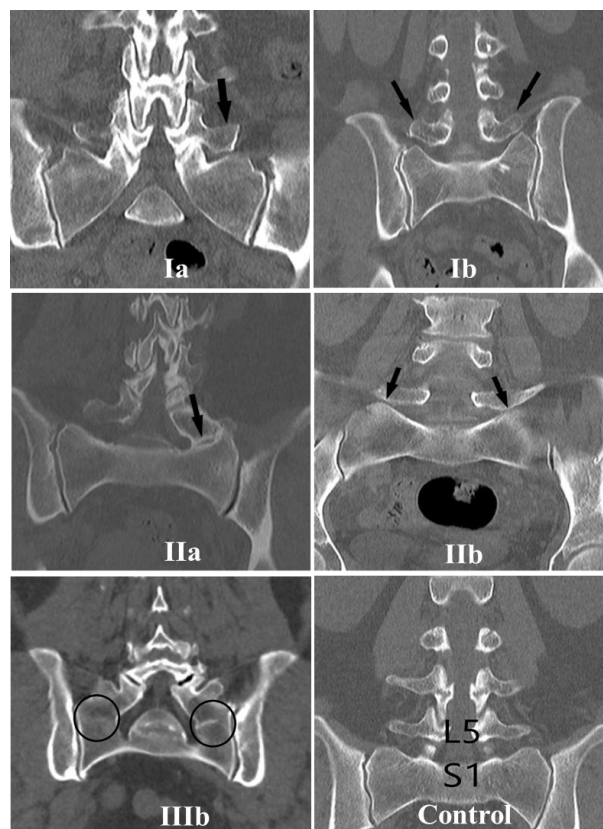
Castellvi classification. Ia= castellvi Type Ia transitional vertebra coronal reformat CT image. Arrow= dysplastic left transverse process; Ib= castellvi Type Ib transitional vertebra coronal reformat CT image. Arrow= dysplastic transverse processes; IIa= castellvi Type IIa transitional vertebra coronal reformat CT image. Arrow= joint between the left transverse process of L5 and the transverse process of S1 vertebra; IIb= castellvi Type IIb transitional vertebra coronal reformat CT image. Arrow= joint between the transverse processes of L5 and S1 vertebrae on both sides; IIIb= castellvi Type IIIb transitional vertebra coronal reformat CT image. Circle= fusion between the transverse processes of L5 and S1 vertebrae on both sides; Control= normal lumbar vertebrae coronal reformat CT image.
